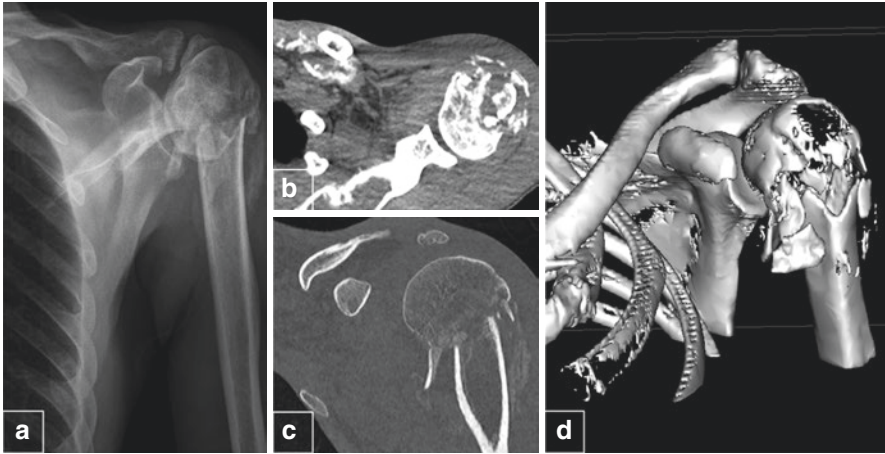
AP radiograph (a), axial CT soft tissue window (b), coronal CT bony window (c), and 3D volume-rendered CT (d) of comminuted left proximal humeral and scapular fractures with dystrophic callus formation in a patient in intensive care. (Images courtesy of Dr. Ganesh Retnasingam MBChB, MRCEd, PGCME, FRCR, Consultant MSK Radiologist, Liverpool University Hospitals NHS Foundation Trust)
